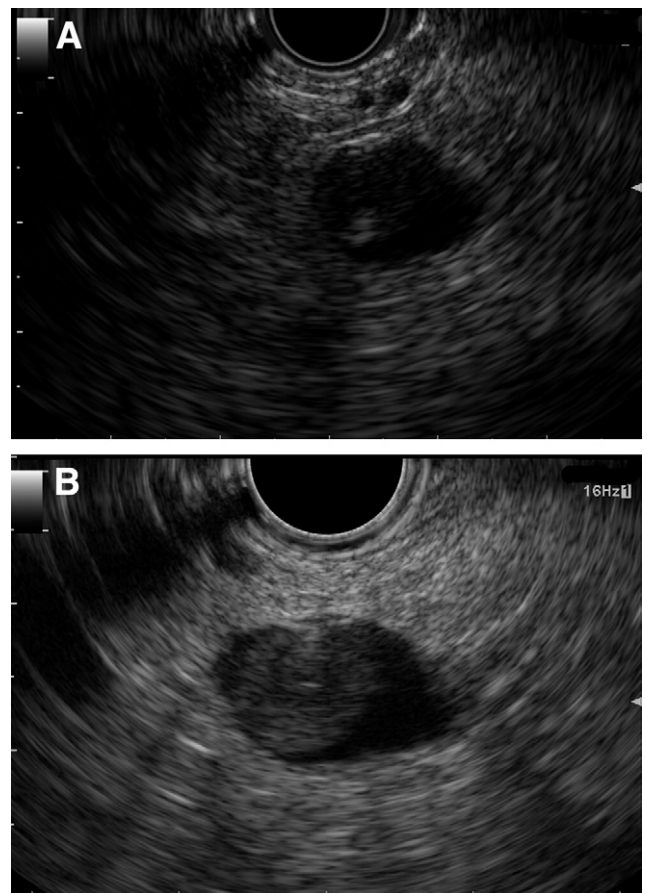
Linear echoendoscope imaging of a pancreatic cyst with internal vegetation in a patient with intraductal papillary mucinous neoplasm. A, Standard endoscopic ultrasound imaging. B, Tissue harmonic imaging allows better appreciation of the internal vegetation and of the boundaries between the cyst and the surrounding parenchyma.
